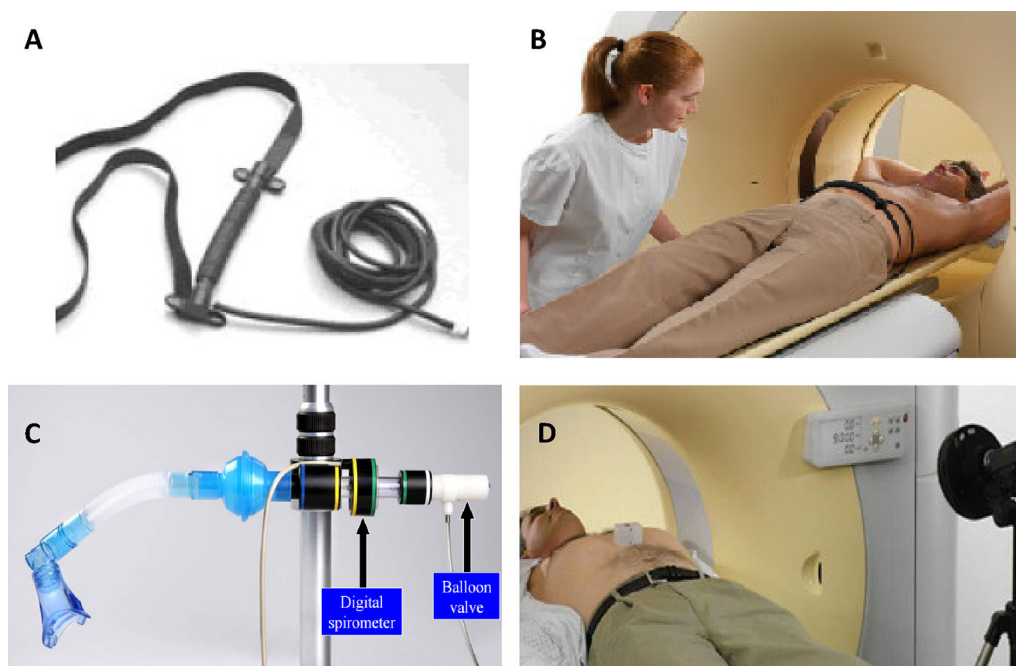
(A) Bellows device. © GE Healthcare Service Shop. (B) Bellows device placed on the patient's abdomen. (C) Active Breathing Coordinator (ABC) device. © 2016 Aktina Medical. (D) Real-time Position Management (RPM) system. http://clinical.netforum.healthcare.philips.com/us_en/Explore/White-Papers/PetCT/Routine-clinical-application-of-4D-Time-of-Flight-PET-CT.
